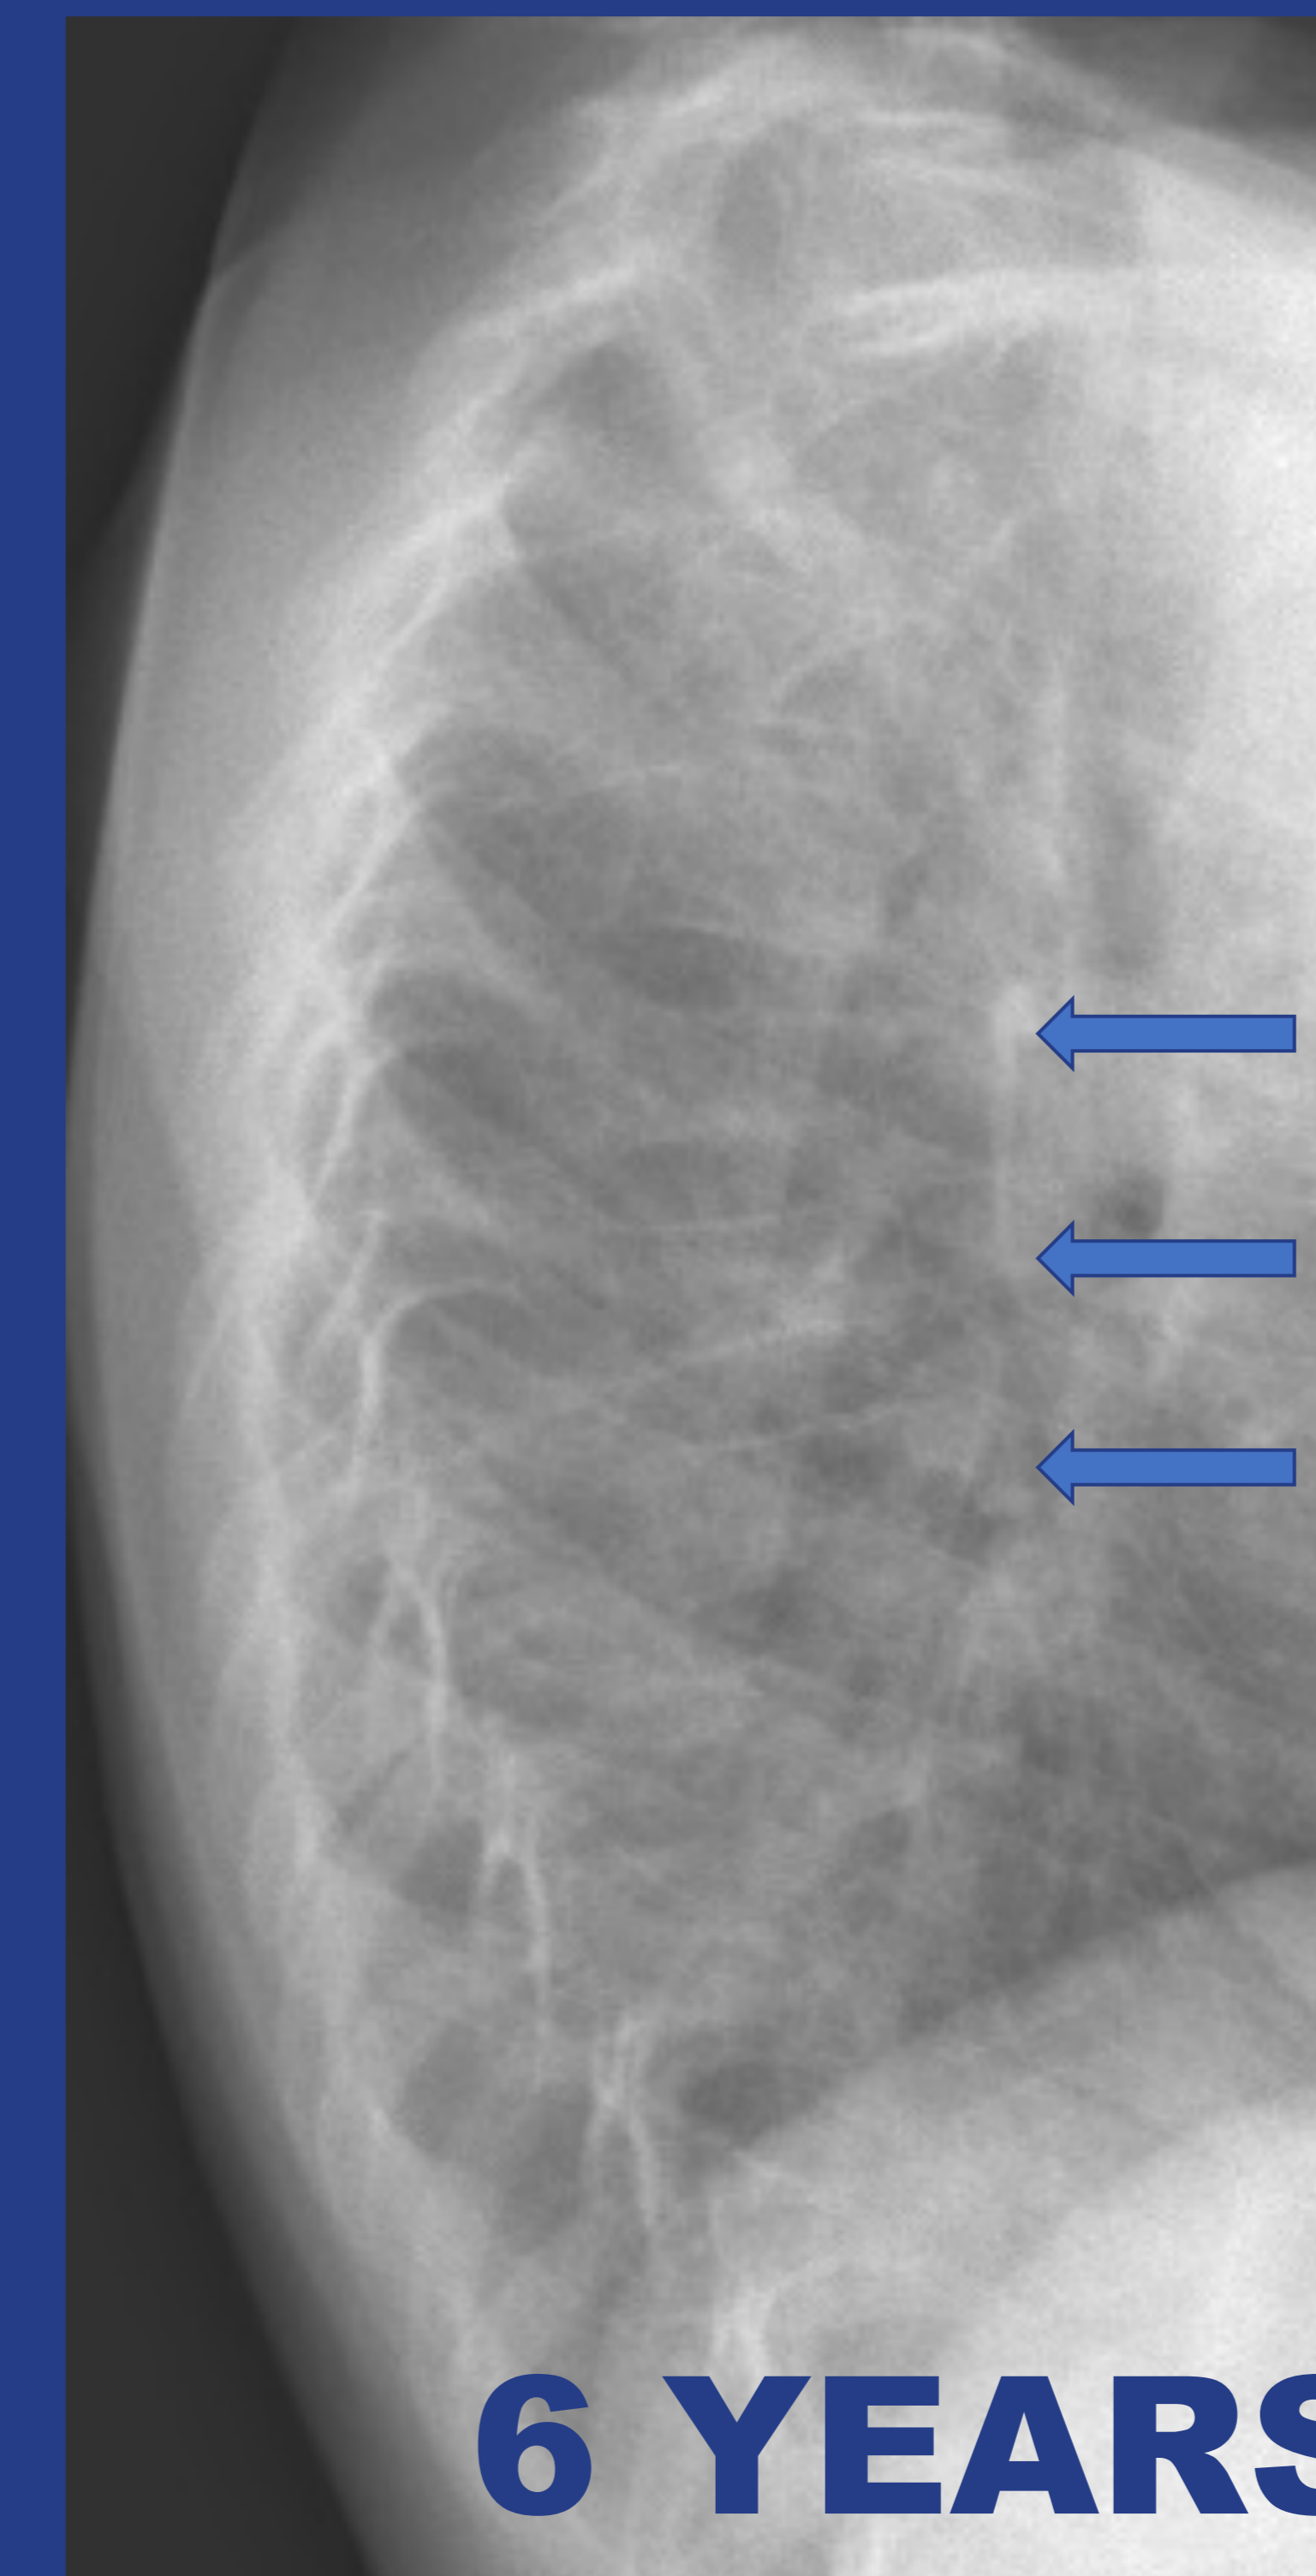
Lateral spine x-rays of the patient taken at the age of 6 years and 17 years. The arrows show the complete reshaping of the original three vertebral fractures
